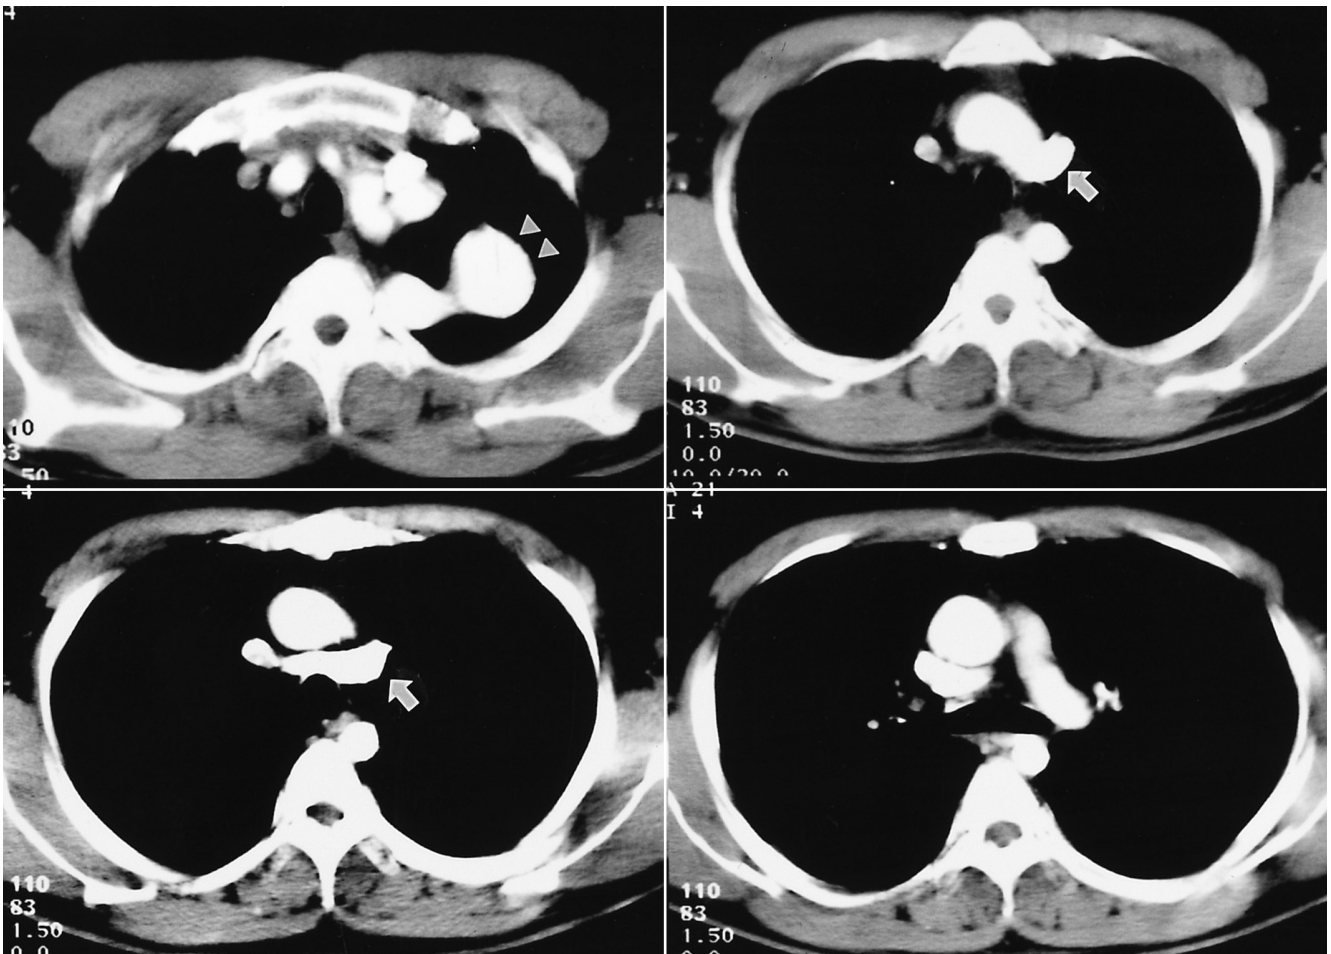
Contrast-enhanced CT shows a tortuous fusiform dilated transverse arch aneurysm (arrowheads). The subaortic left innominate vein (arrows) is noted.
